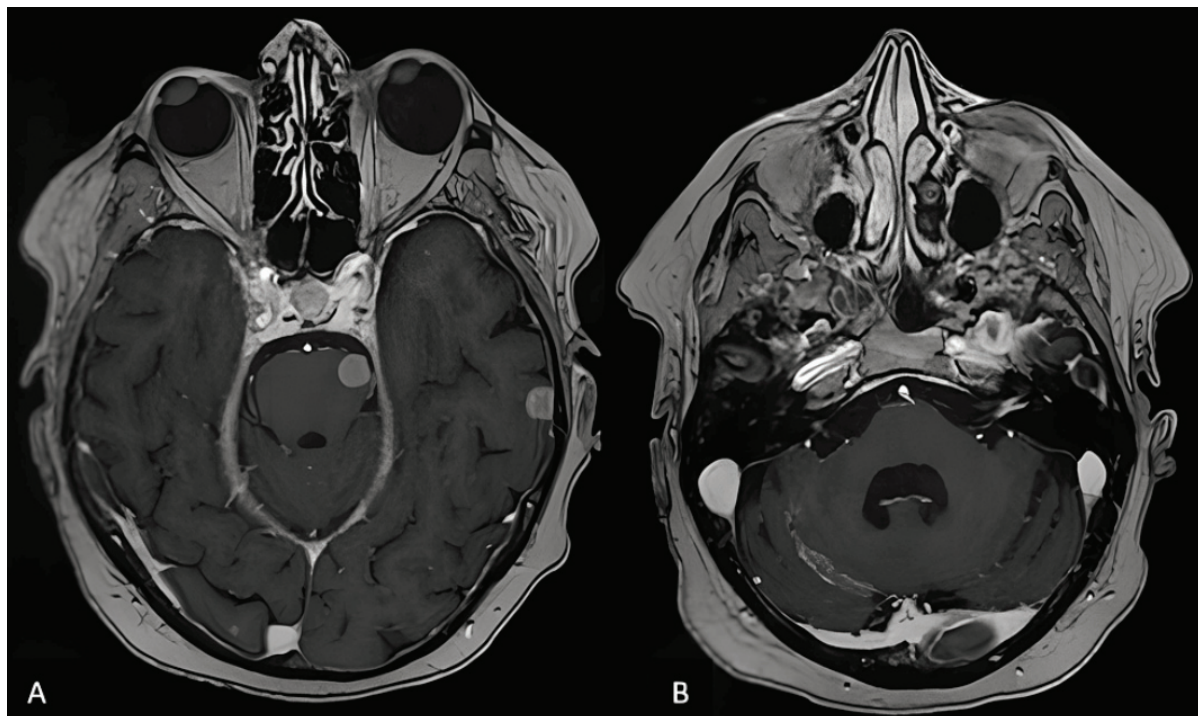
A: A brain MRI of case 2 was performed in October 2018 before starting lorlatinib, with evidence of pontine and left temporal brain metastases. B: MRI scan with evidence of cerebellar leptomeningeal carcinomatosis.
